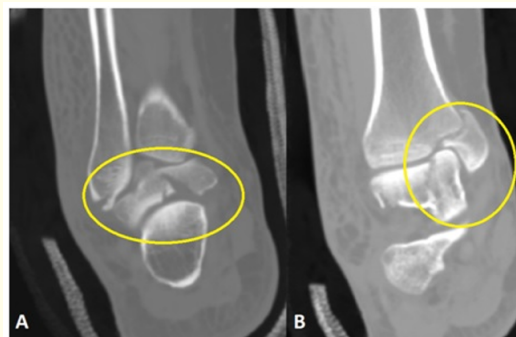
A: CT scan of Right ankle coronal cuts showing comminuted talar body fracture with articular involvement and lateral malleolar fracture. B: CT scan of Right ankle coronal cuts showing medial malleolar fracture with talar neck fracture.
